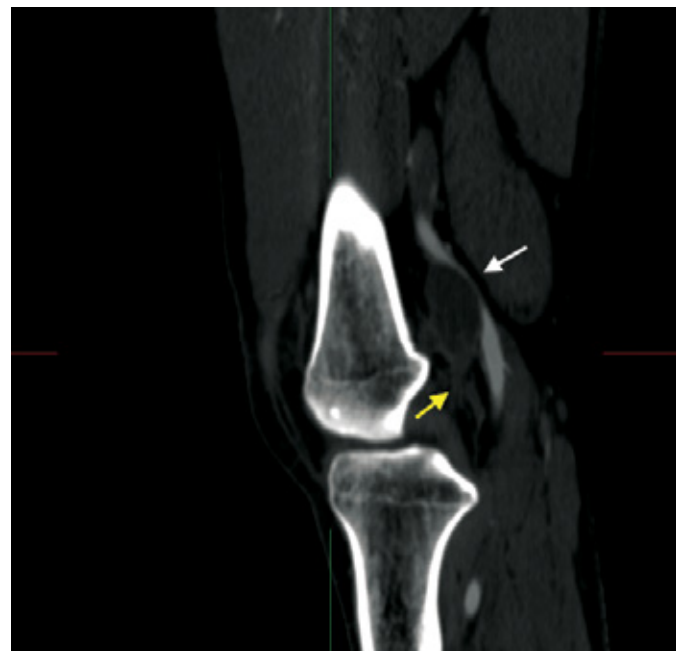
Preoperative CTA image with scimitar sign, the cystic lesion of the popliteal artery (white arrow) and the ligament connecting it to the knee joint (yellow arrow)
